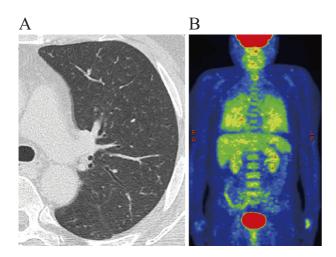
Chest CT (A) and ¹⁸F-FDG PET-CT (B) scans at the initial presentation, showing diffuse multiple small nodules in the lung fields and an increased diffuse FDG uptake in both middle-lower lung fields. FDG: fluorodeoxyglucose, PET: positron emission tomography
